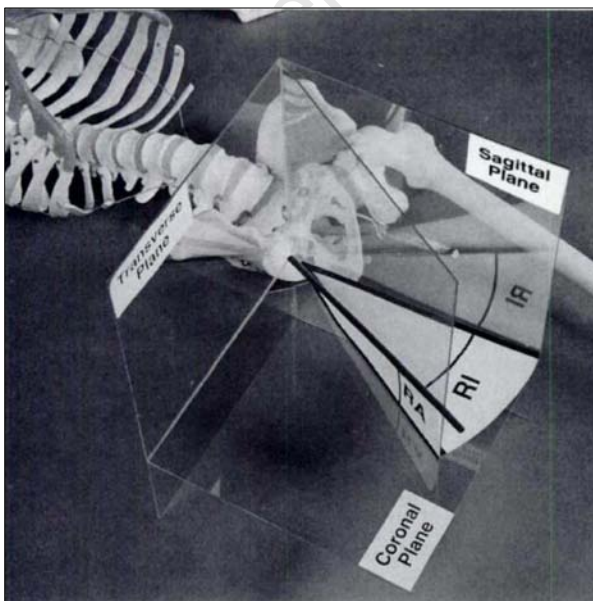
Image showing radiographic anteversion (RA) and radiographic inclination (RI), relative to the right acetabulum socket, adapted from (Murray 1993).
